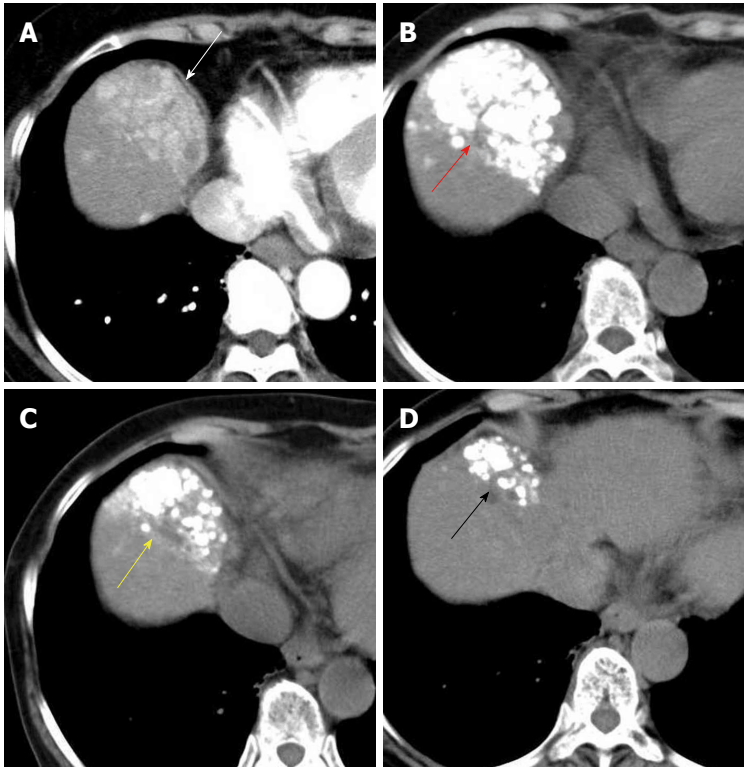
A 74-year-old woman with hepatitis-C related multiple hepatocellular carcinoma. A: Contrast-enhanced computed tomography (CT) showed that multiple HCC nodules were observed, aggregated at segment 8 (white arrowhead); B: Computed tomography showed that the dense lipiodol emulsion (LE) accumulations (red arrowhead) were observed just after balloon-occluded transcatheter arterial chemoembolization (B-TACE) for multiple HCC; C: We carried out additional B-TACE because local recurrence was detected on follow-up CT. Favorable LE accumulations were observed just after additional B-TACE (yellow arrowhead); D: Three month after additional B-TACE, local recurrence was not observed, and the LE accumulations were shrinking (black arrowhead). HCC: Hepatocellular carcinoma.
